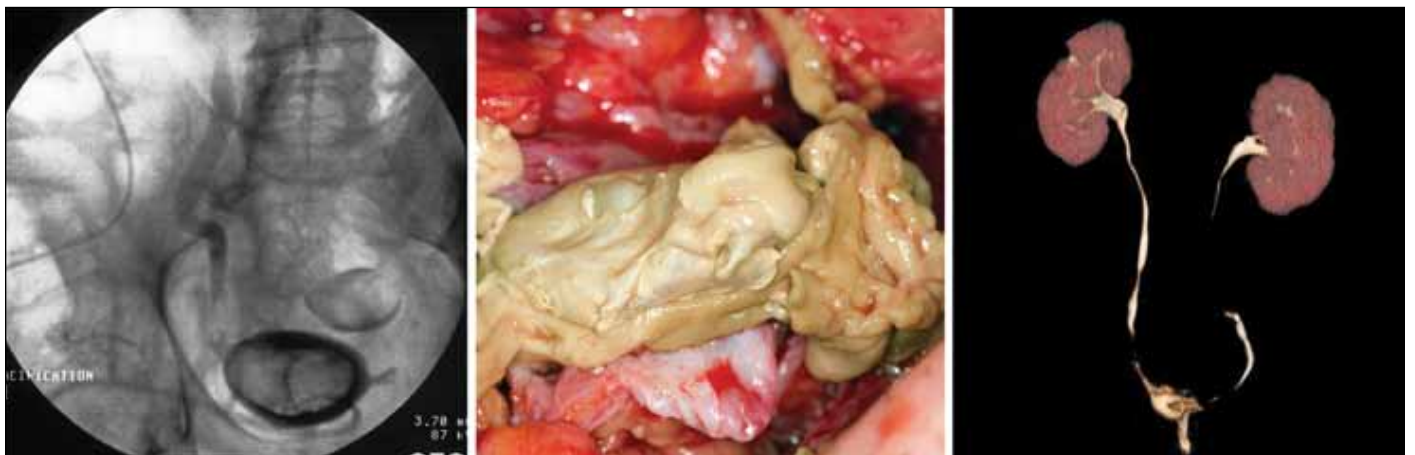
A: Right nephrostogram showed a distal ureteral defect associated with a large defect in the bladder and a diverticulum B: Fungus ball relief demonstrated a white soft tissue. C: A computed tomography scan reconstruction 2 months after right reimplantation.
